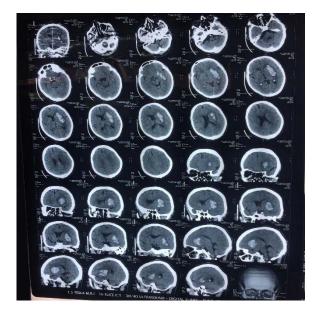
CT-scan images of patient no. 3
